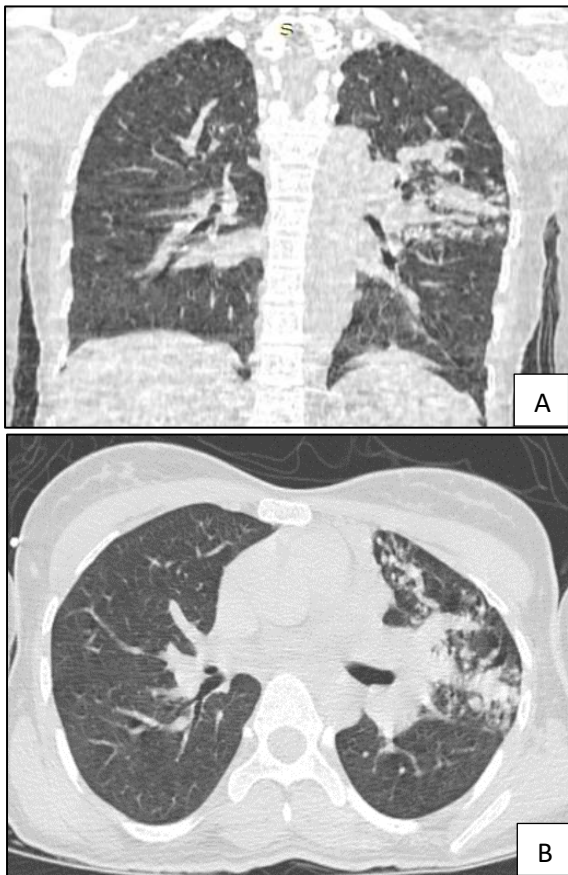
(A) Coronal section of HRCT Thorax reveals: multiple solid and ground glass nodules in anterior and lingular segments of left upper lobe-likely telangiectatic stage of PAVMs. (B) Axial section of HRCT Thorax reveals: multiple solid and groundglass nodules in anterior and lingular segments of left upper lobe- likely telangiectatic stage of PAVMs.
